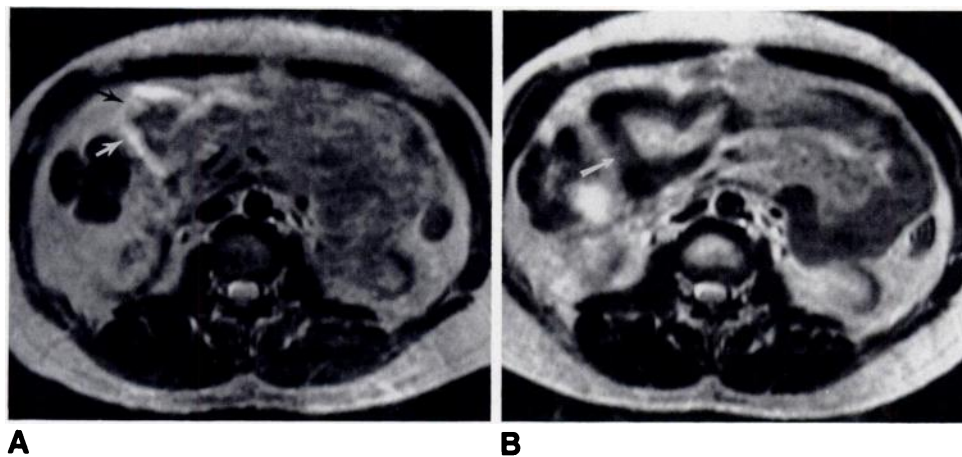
Axial T2-weighted MR images of proximal small bowel.
